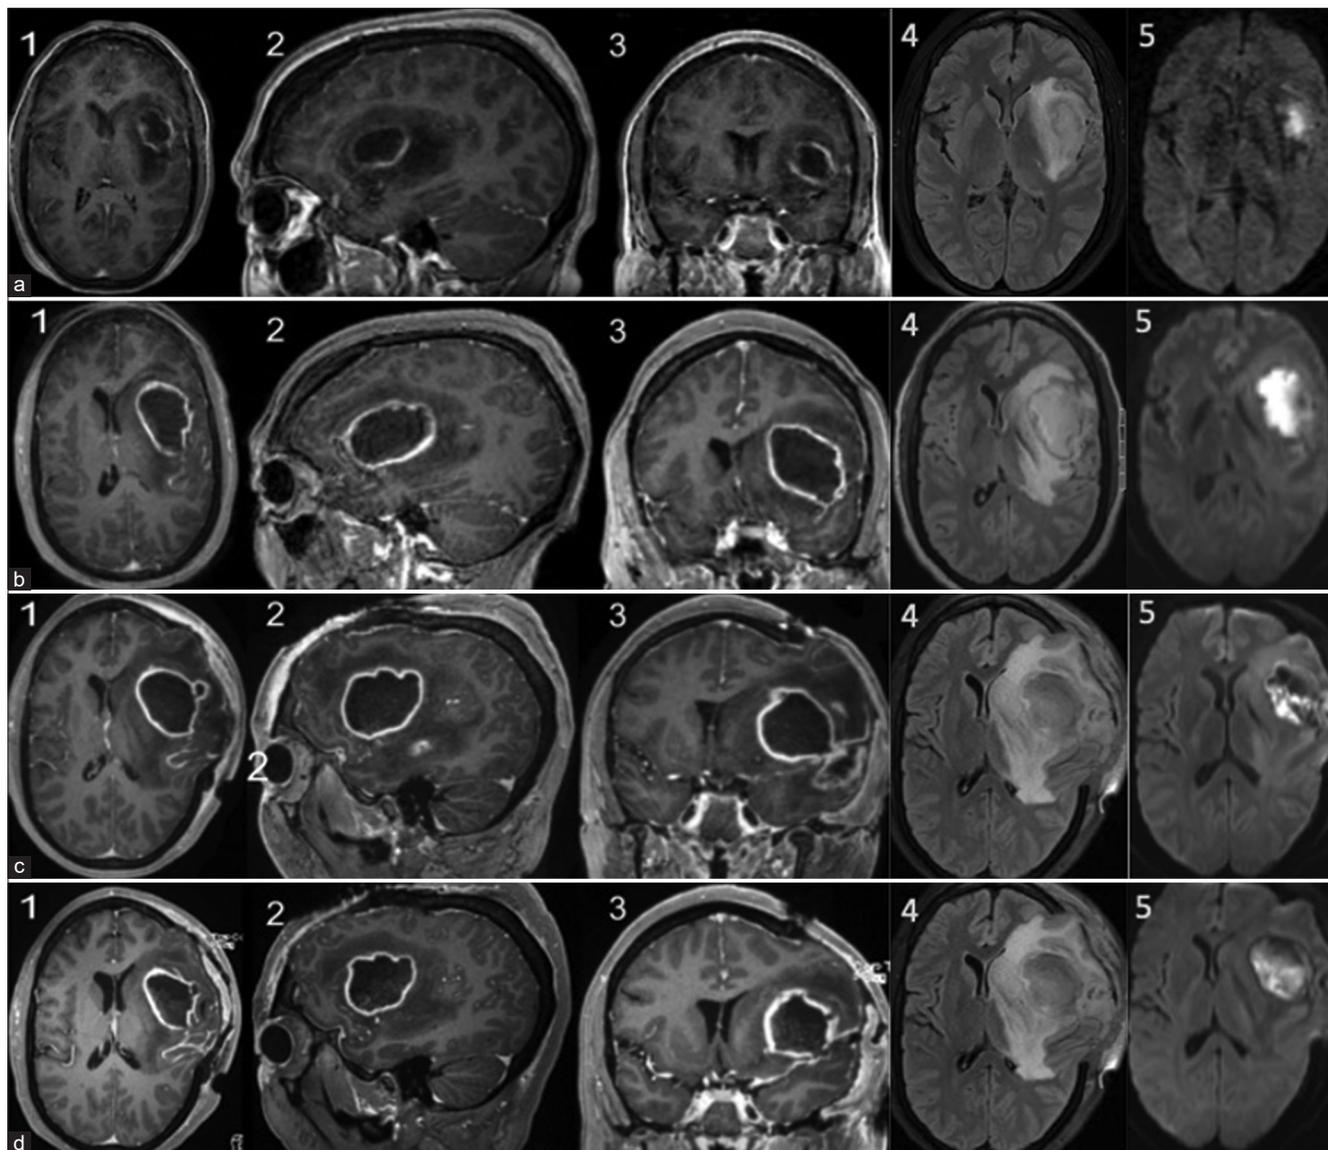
Serial brain magnetic resonance imaging (MRI) scans performed throughout the patient's hospital course: (a) on admission to MGH showing left insular mass with irregularly marginated peripheral enhancement with central necrotic and hemorrhagic foci causing mass effect and a 2 mm midline shift to the right. Fluid-attenuated inversion recovery (FLAIR) imaging demonstrates surrounding edema and diffusion-weighted imaging (DWI) demonstrates restricted diffusion in the center of the lesion. (b) Following acute clinical decline before first surgery revealed an interval increase in the left insular lesion with more well-defined peripheral enhancement. Mass effect has progressed causing increased rightward midline shift. FLAIR imaging shows increased peripheral edema. (c) Postoperative demonstrating a mildly decreased size in the lesion. There is a loculated rim-enhancing component along the superolateral margin of the resection cavity and a focus of apparent discontinuous rim enhancement along the inferolateral posterior aspect of this loculation. (d) Surveillance MRI on post operative day 7 shows an expansion of the previously partially collapsed appearance of the abscess cavity walls. Extensive FLAIR hyperintensity with mass effect surrounding the abscess cavity has increased causing increased extracranial herniation and left to right midline shift. The images show T1 postcontrast axial (labeled as 1), sagittal (labeled as 2), and coronal (labeled as 3); axial FLAIR (labeled as 4); and axial DWI (labeled as 5).
